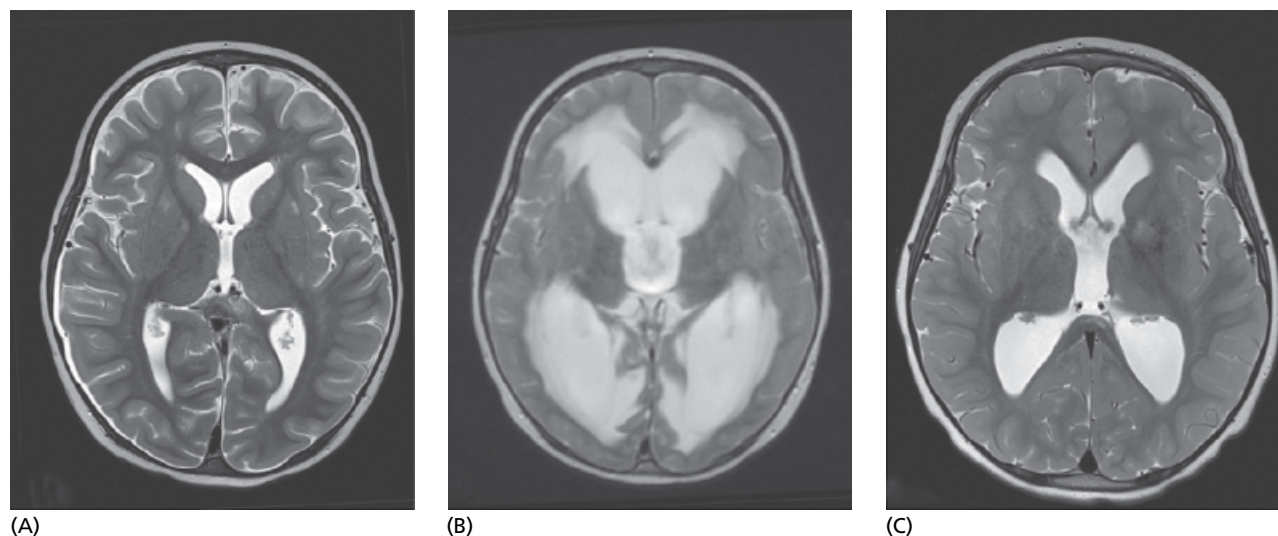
MRI of child with postmeningitic hydrocephalus before and after treatment. (A) Brain T2 MRI showing mild ventriculomegaly with very early stage hydrocephalus development in a child aged 22 months with meningitis. (B) Brain MRI of same child 2 weeks later showing severe hydrocephalus with severe ventriculomegaly and increased extracellular water in the periventricular white matter. (C) Brain MRI of same child 9 months after endoscopic third ventriculostomy and choroid plexus cauterization with resolution of hydrocephalus and clinical recovery. *Source:* Reproduced from Kahle et al [155] with permission of Elsevier.
